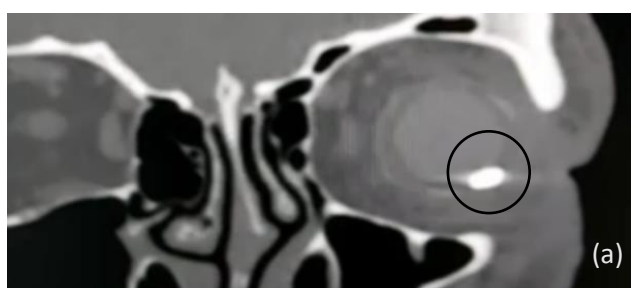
(a) Coronal view (b) axial view of CT scan of orbit showing hyperdense foreign body noted abutting the ocular coat and located in the intraconal space of the left orbit.
